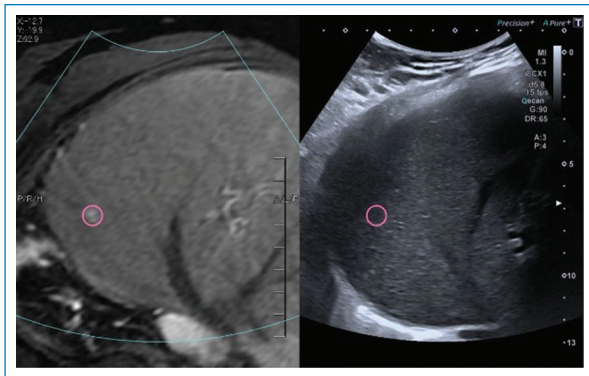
Synchronized images of an image fusion between MRI and ultrasound prior to the ablation of a small HCC (the pink ROI indicates the location of the lesion and the ablation margin to perform). On the left, the MRI shows a small hyperintense lesion, and on the right, the intraprocedural ultrasound where this lesion is not visible. HCC: hepatocellular carcinoma; MRI: magnetic resonance imaging; ROI: region of interest; US: ultrasound.
